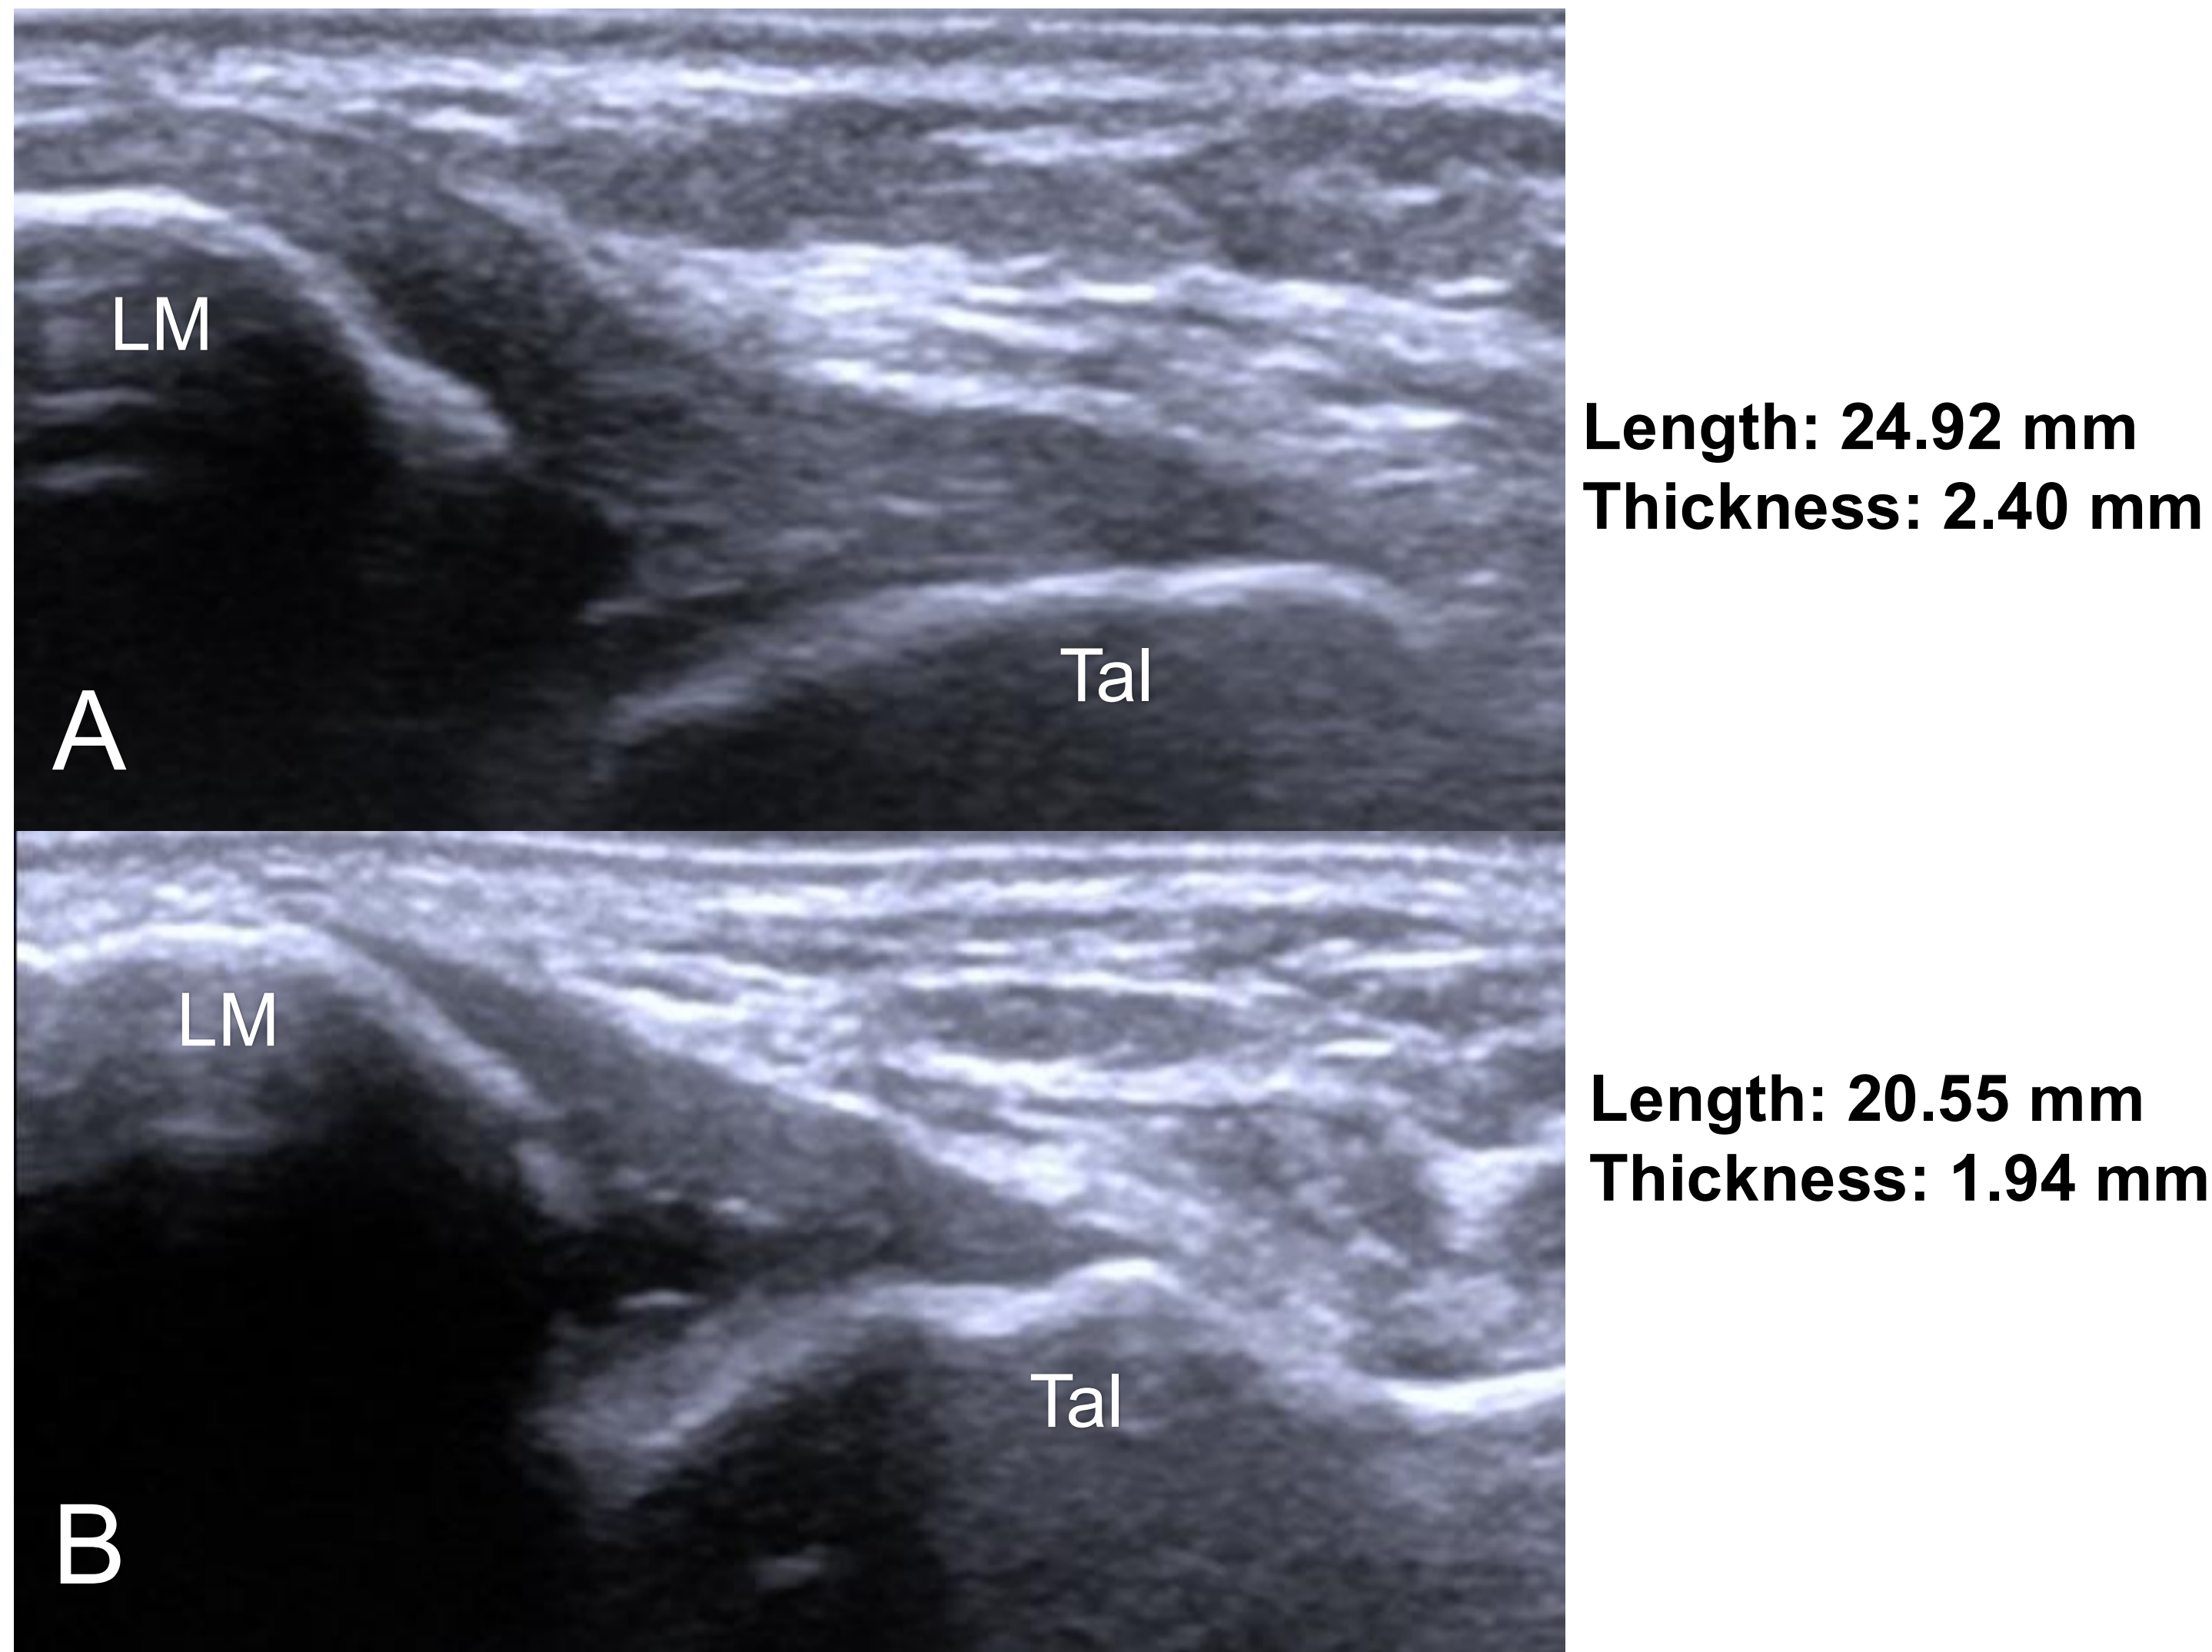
Representative ultrasound images demonstrating increased ATFL thickness in a participant with CAI (A) compared with an ATFL with no previously reported injury (B). LM: Lateral malleolus, Tal: Talus
